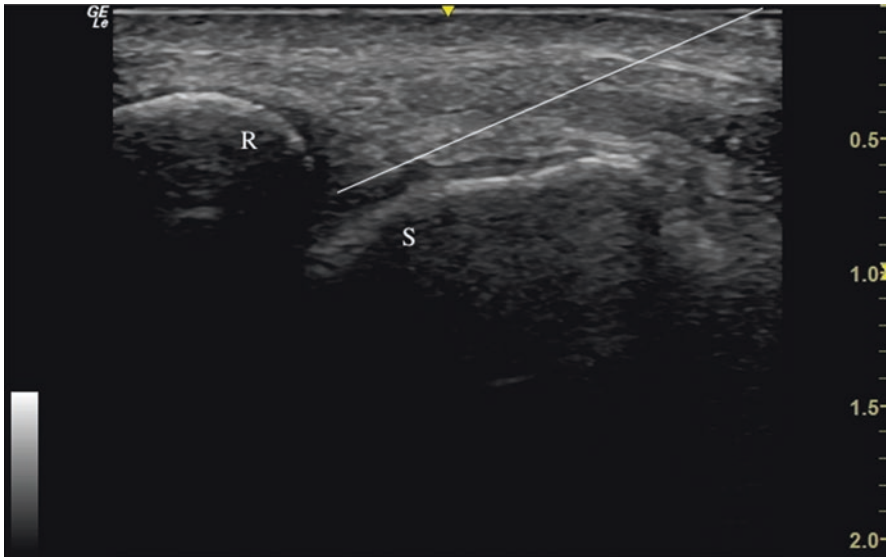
Ultrasound image for radiocarpal injection. Ultrasonogram. *R* radius, *S* scaphoid
